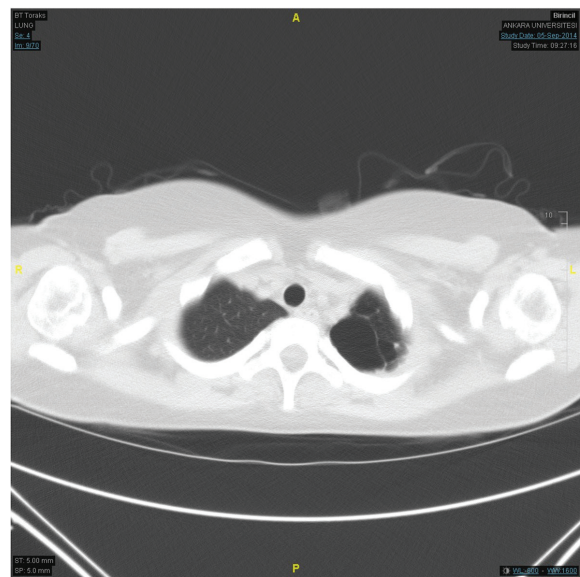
CT scan of spontaneous pneumothorax
